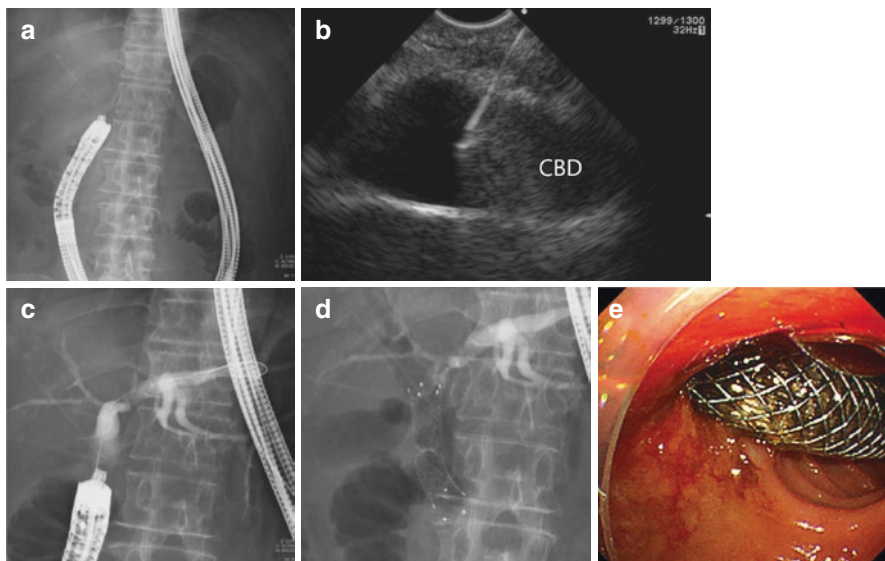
EUS-CDS technique. (a) EUS scope is advanced into duodenal bulb via long position. (b) Doppler visualization is confirmed and CBD is punctured using 19-G needle. (c) Guide wire is advanced toward the hepatic hilum to the IHBD. (d) Fully covered self-expandable metal stent deployed. (e) Endoscopic view of SEMS via transduodenal fistula
